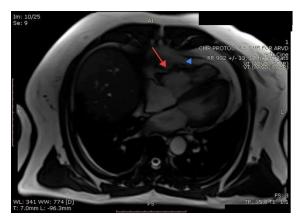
MRI showing diffuse thinning of RV wall (blue arrowhead) and aneurysmal dilatation of subtricuspid RV free wall (red arrow) suggestive of ARVC
